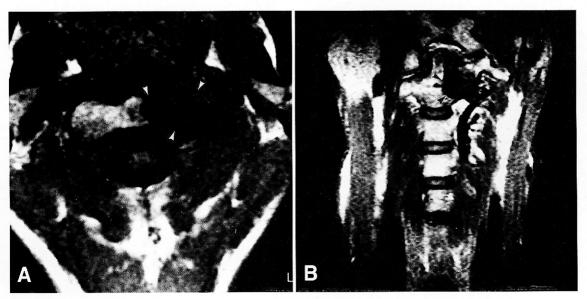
Axial (A) and sagital (B) views of Magnetic resonance images showing a signal-void mass at the C-2 vertebral body.
